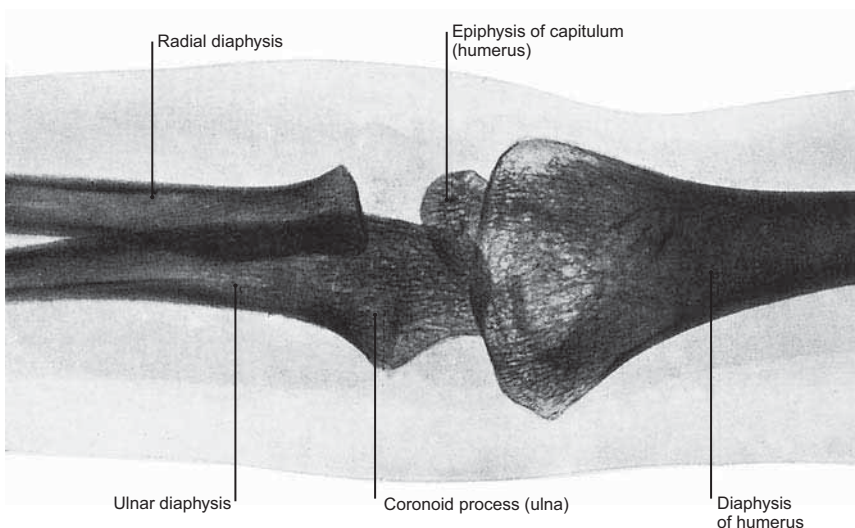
Radiograph of the Elbow Joint in a 5½-Year-Old Boy
